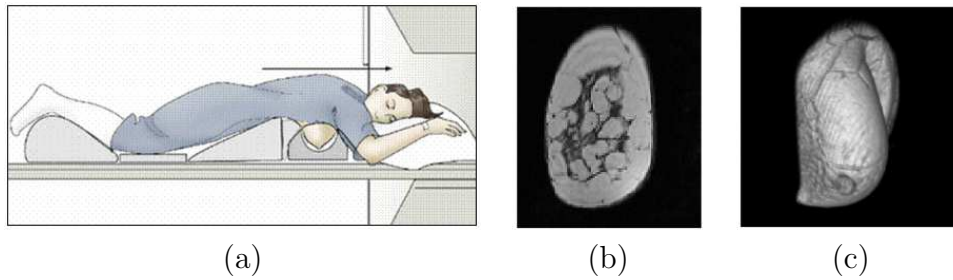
MRI: (a) breast MR imaging acquisition, (b) MR slice and (c) volume rendering. Typical slice resolutions around 256×256 or 512×512 and 8 bits per pixel.
